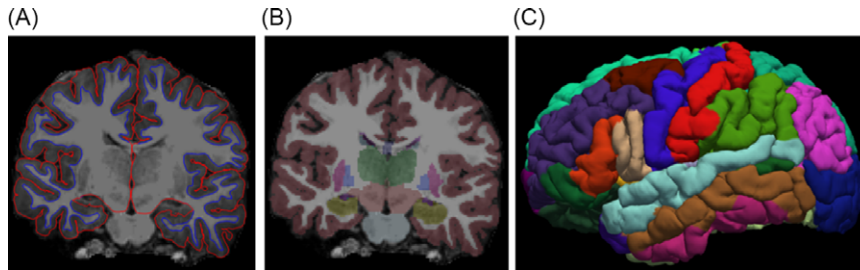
Preprocessing of MRI data using FreeSurfer. A–B. Inspection of cortical segmentation and surface reconstruction of images. C. Inspection of atlas parcellation using the Desikan–Killiany atlas.
